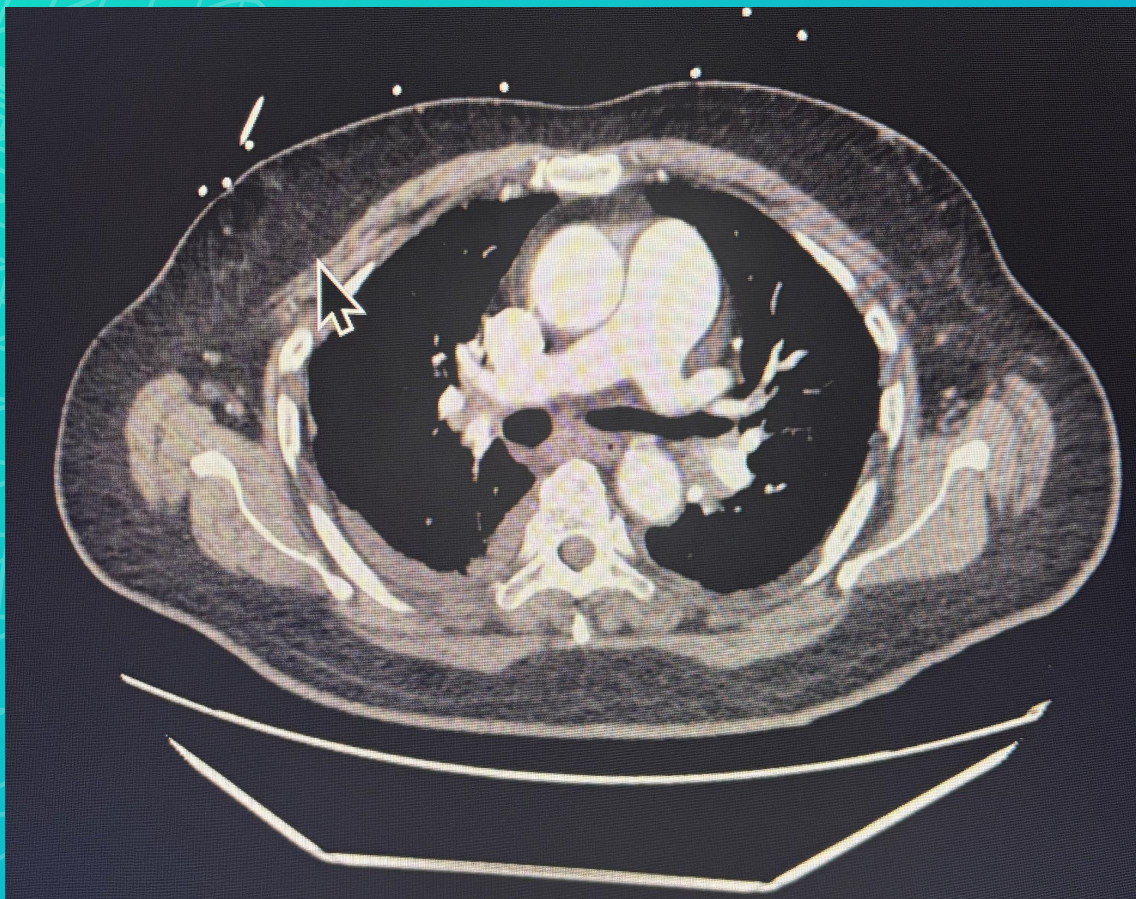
CT of chest showing main pulmonary artery at bifurcation filled with contrast..indicating a filling defect (no thrombosis).
